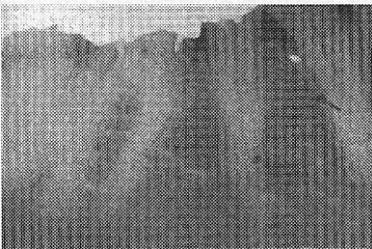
Radiograph of an osteoporotic woman with “focal osteoporotic bone marrow defects” on both sides of the second premolar.
